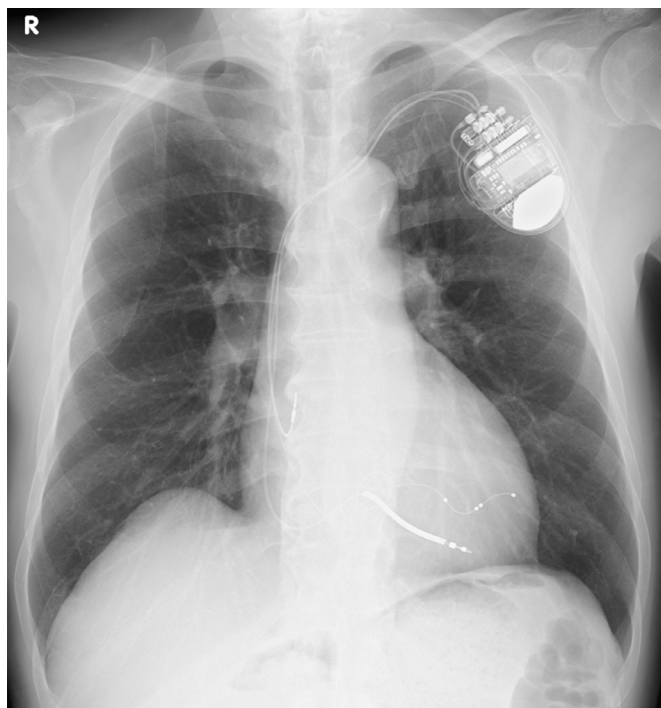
Chest X-ray at the 2-year follow-up showing a cardiothoracic ratio of 49% with no pleural effusion.
